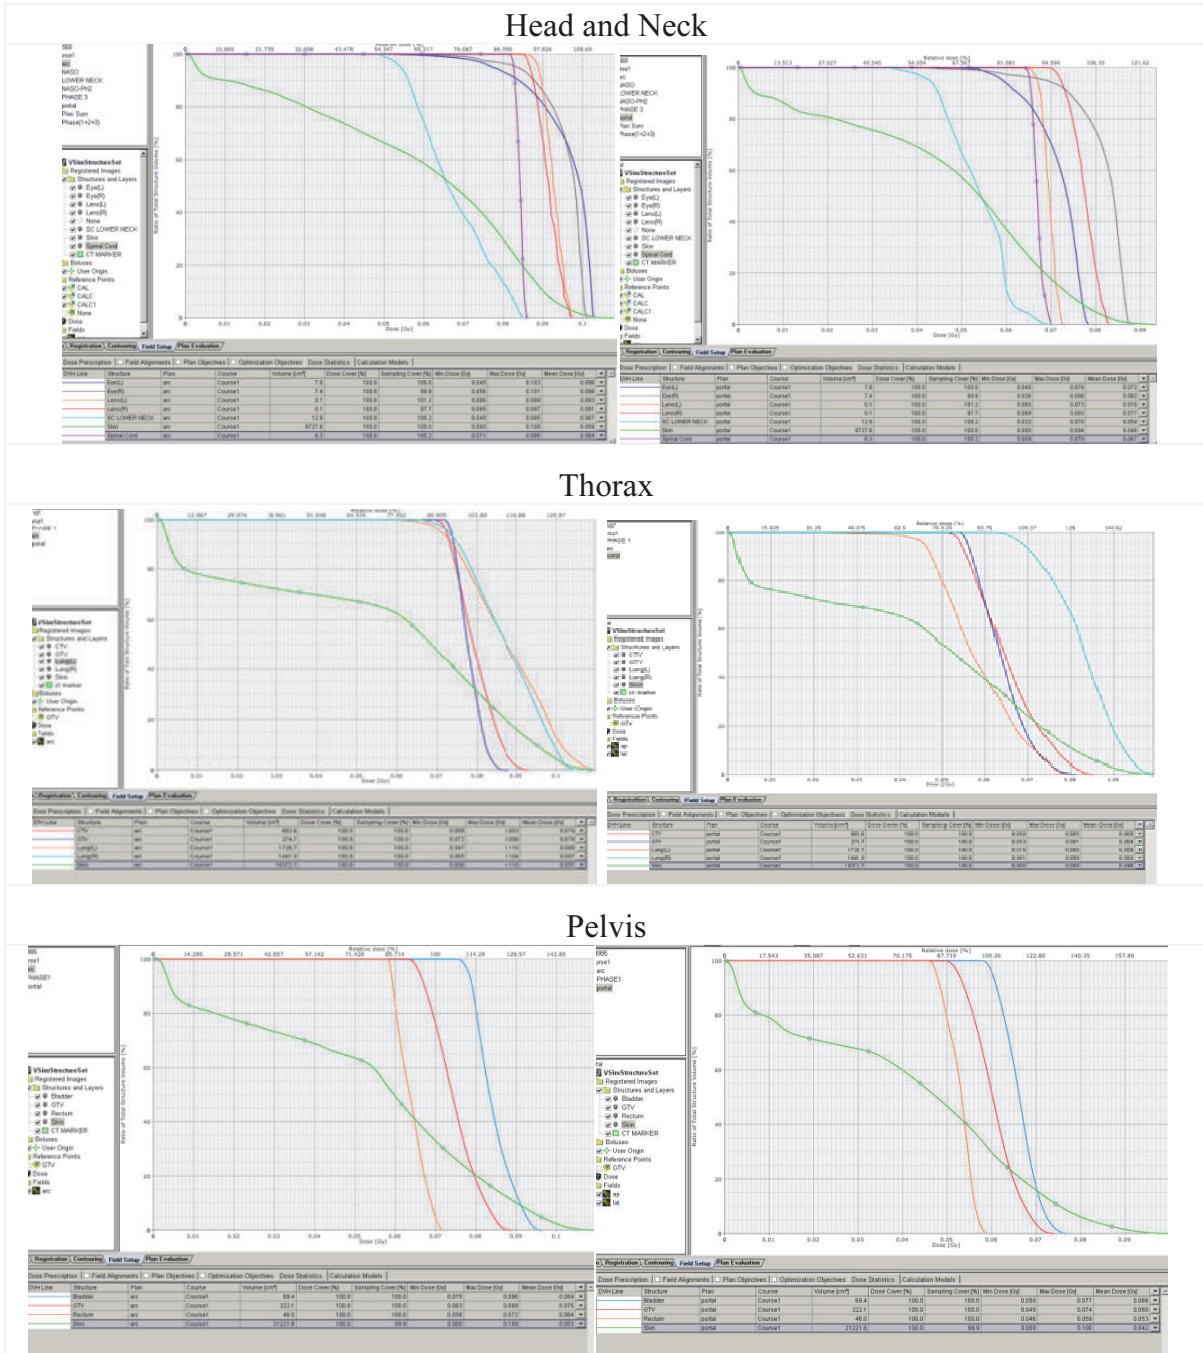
The dose-volume histogram of tumor (GTV/CTV/PTV) and all critical organs evaluated in various treatment sites using MV CBCT imaging with 8 MU (left panels) and orthogonal portal imaging with 6 MU (right panels).
